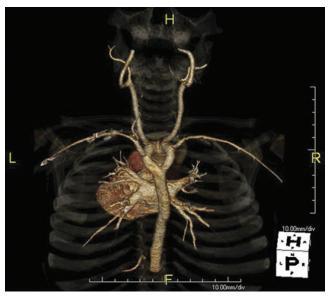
This carotid computed tomography (CT) scan was reconstructed from a 64-slice spiral CT examination. (Courtesy Lance Blackwell, TeraRecon, Inc.)
